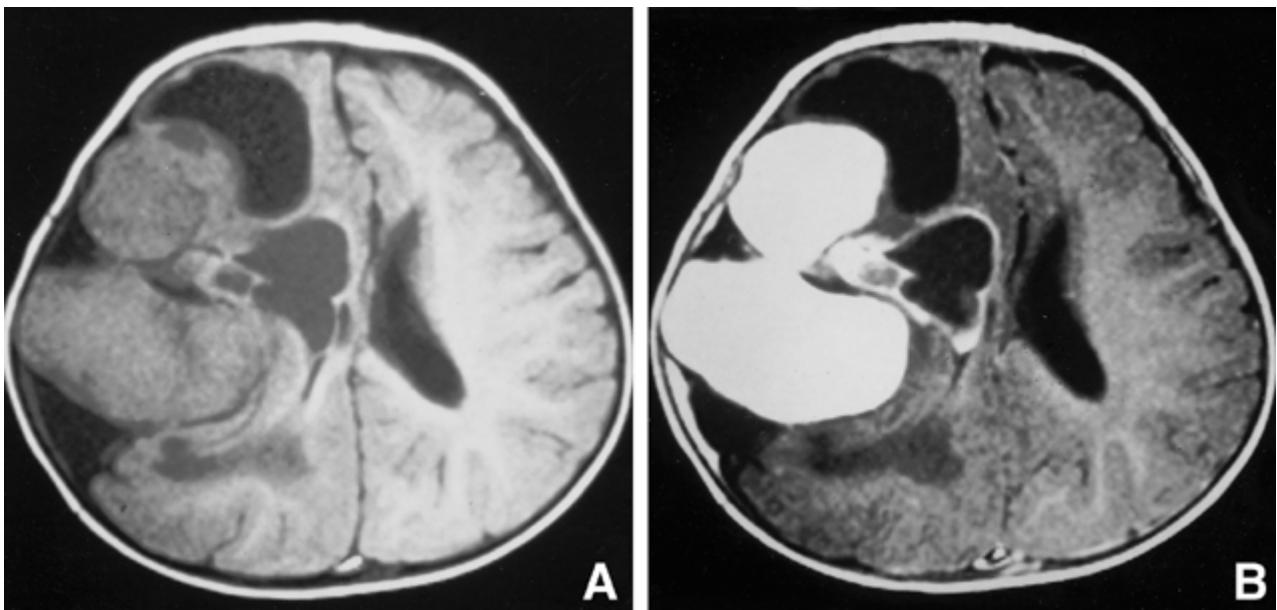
(A) MR T1-weighted image of brain showed an iso- or hypointense lobulating mass with cystic lesion in the right fronto-temporo-parietal lobe. (B) MR T1-weighted contrast-enhanced image revealed enhancement of solid portion.
